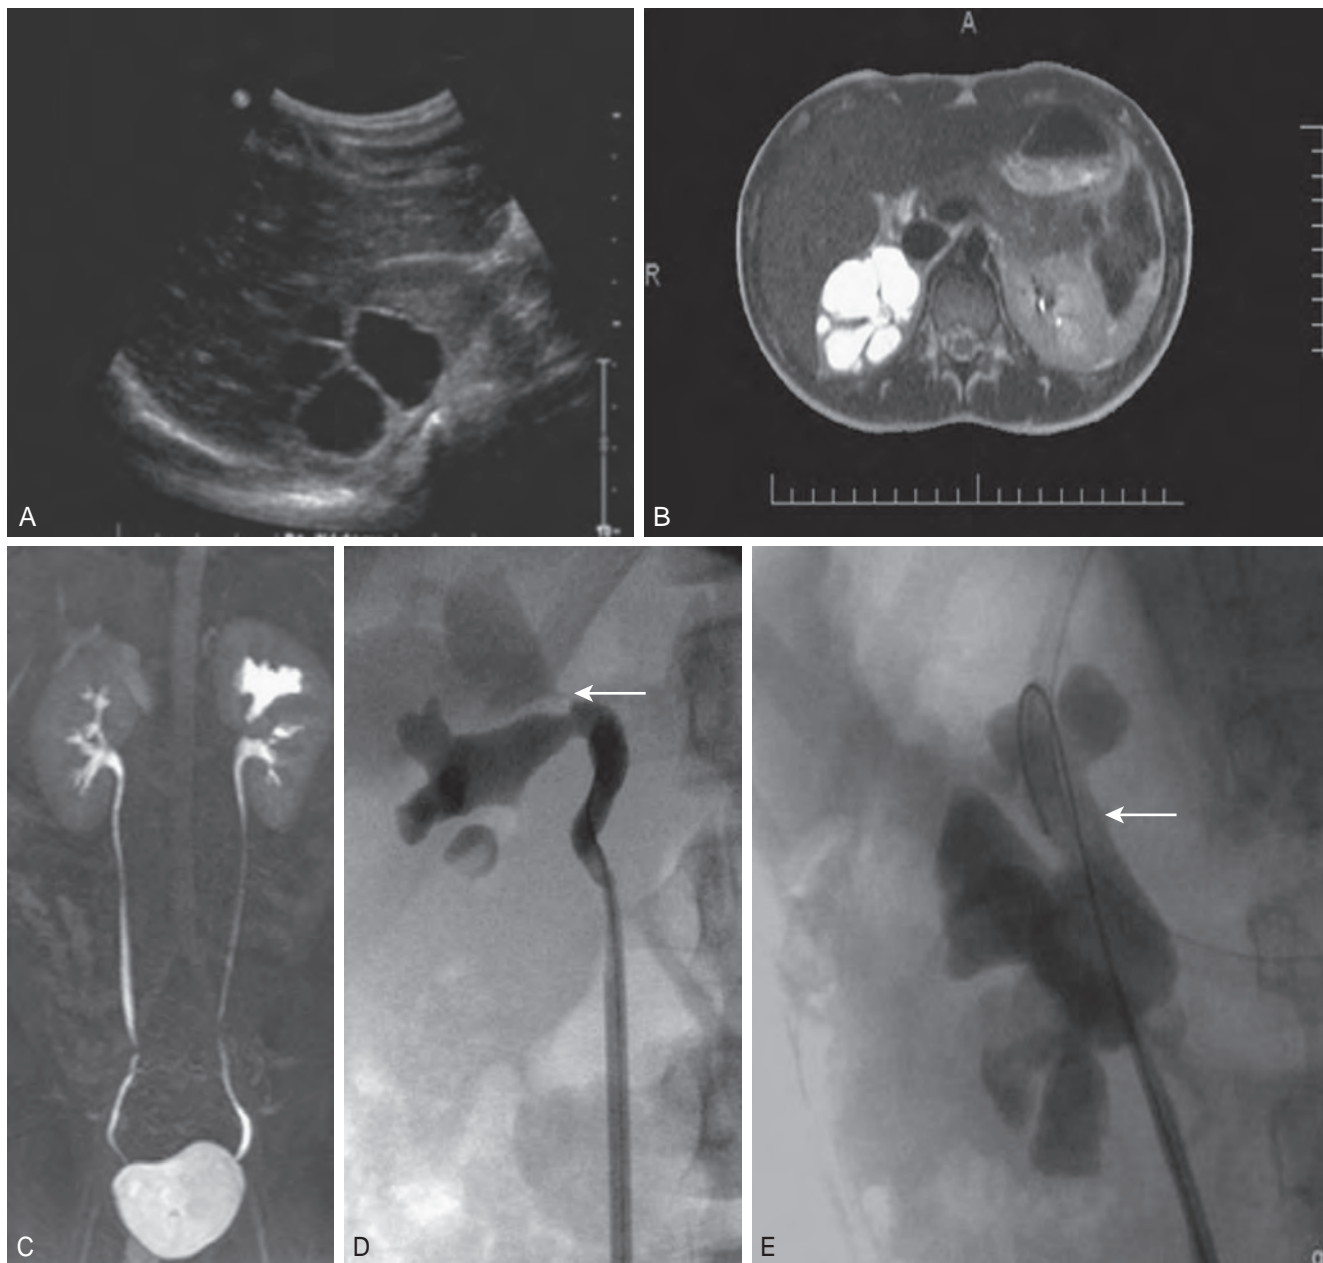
Infundibular stenosis of right upper pole calyx. A, Sagittal sonogram. B, Axial T2 images. C, Coronal magnetic resonance urogram. D, Right retrograde pyelogram shows no filling of the stenotic infundibulum (arrow). E, Right retrograde pyelogram following laser incision and balloon dilation of the infundibulum (arrow). (Courtesy Dr. Pasquale Casale.)
